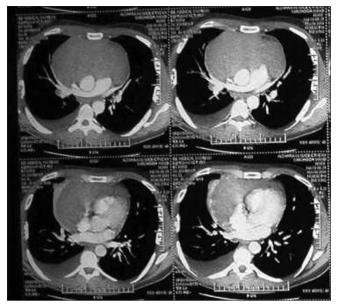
Chest CT scan of patient
